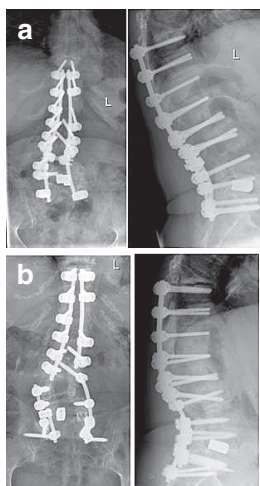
Case 1: Preoperative X-rays (Posterior fusion T10-T12, ALIF L1-L5, PLIF L5-S1, and old T9 fracture with regional hyperkyphosis) with pseudarthrosis L5-S1 and loosening of both screws in S1 (a). Postoperative X-rays after removal of the hardware L3-S1 on the left side and L4-S1 on the right side with rod transection, new instrumentation with accessory instrumentation of both sacral ala, removal of the left cage in L5-S1, autologous bone grafting in L5-S1 with application of a new titanium cage, cement augmentation of the right pedicle screw in S1, and application of a 10 mm S1 screw on the left side. Stable conditions at 1-year follow-up (b).
